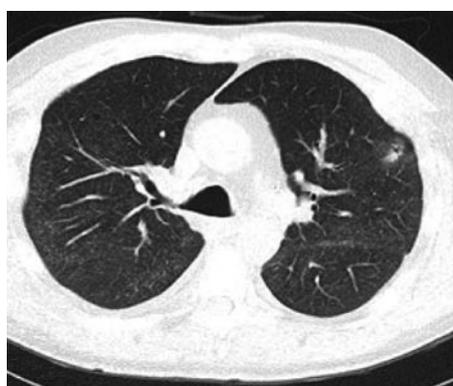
Computed tomography of chest revealing a cavitating lung nodule involving lingual. A transbronchial biopsy was obtained from the site 21 d earlier.
